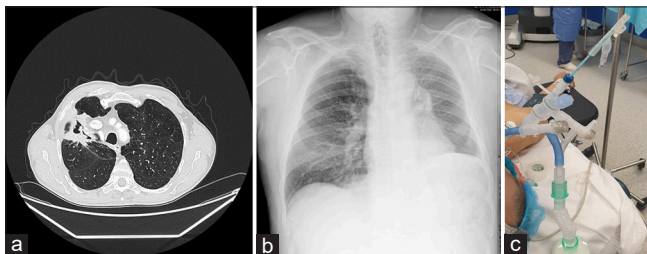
(a) Neoplasia inside a tuberculosis cavity in a CT. (b) X-ray of a patient with a left lower lobectomy. (c) View from a 37F left VivaSight© DLT of a bronchial blocker in the intermedium right bronchus
